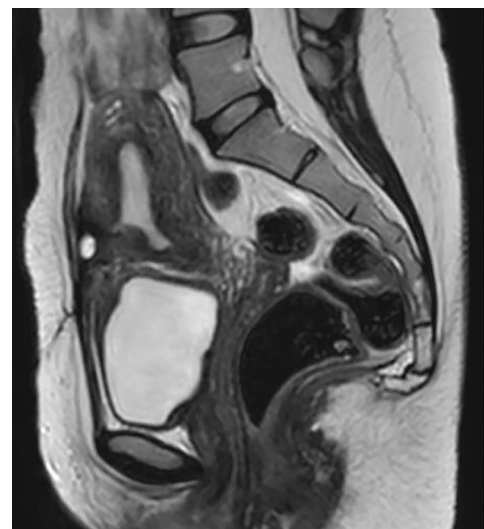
Magnetic resonance imaging sagittal view showing ventrofixated uterus and the lesion of uterine scar endometriosis measuring about 1.5x1x1.3cm.
